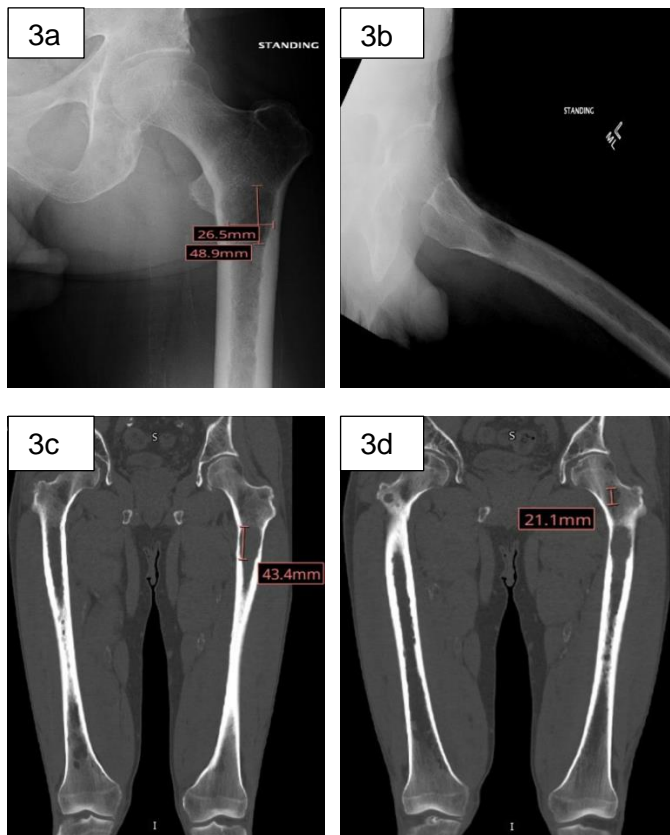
X-ray and CT images of the left femur taken 6 months after initial diagnosis demonstrating enlargement of the left proximal femoral subtrochanteric lesion. (3a) AP view X-ray with marker demonstrating left proximal femoral subtrochanteric lesion size. (3B) Lateral view X-ray (3C) CT scan with marker demonstrating proximal femoral subtrochanteric lesion size.(3d) CT scan with marker demonstrating left femoral intertrochanteric lesion size.
